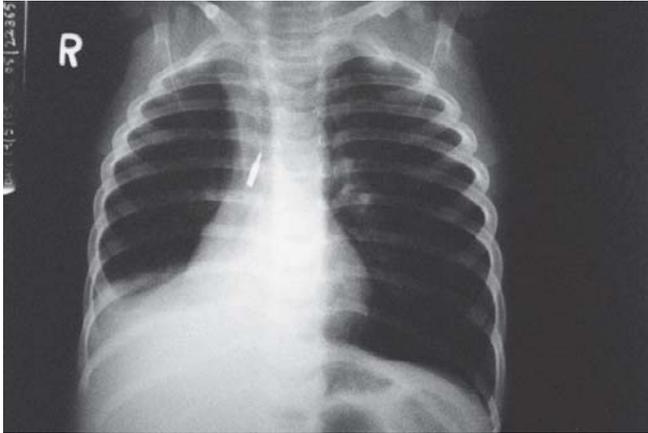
Chest radiograph showing small pen tip in right mainstem bronchus
